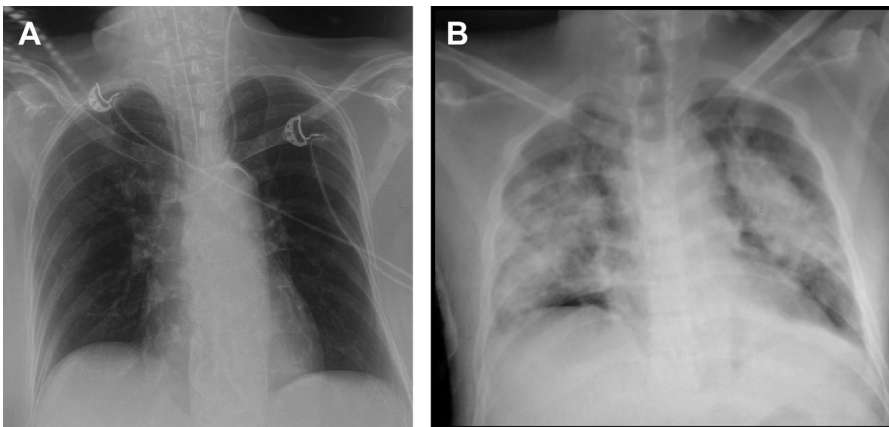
(A) Chest radiograph of a patient with acute pancreatitis and respiratory failure with PaO₂/FiO₂ = 80. Lung parenchyma is relatively clear. (B) Chest radiograph of a patient with coronavirus disease 2019 infection and acute respiratory distress syndrome with PaO₂/FiO₂ = 80. There is diffuse parenchymal infiltrate in all the lung fields.
